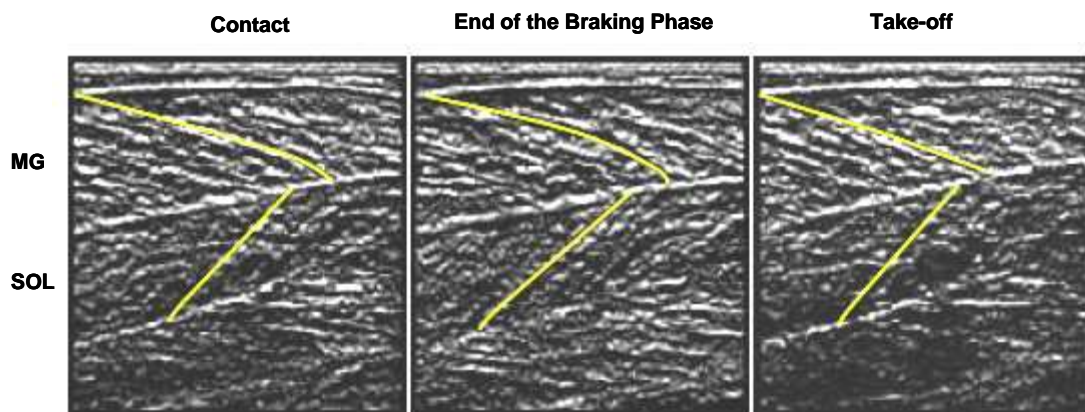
A typical example of the sequence of longitudinal ultrasonic images of the MG and SOL muscles during the drop jumps. Each longitudinal ultrasonic images was recorded at 96 Hz.
